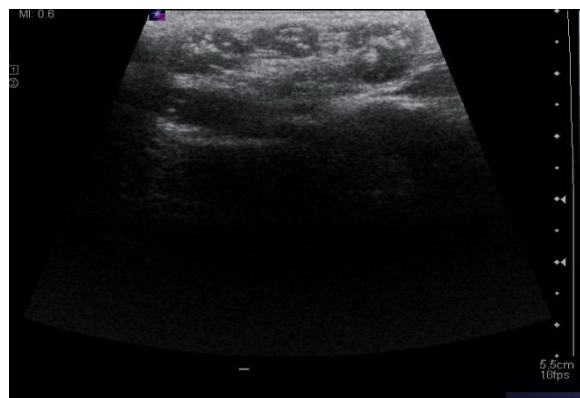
Ultrasound Doppler of right inguinal mass showing Multiple nodular densities with calcifications in the right inguinal region most likely represent calcified inguinal nodes largest 1.2 x 0.7 x 1.0 cm.
